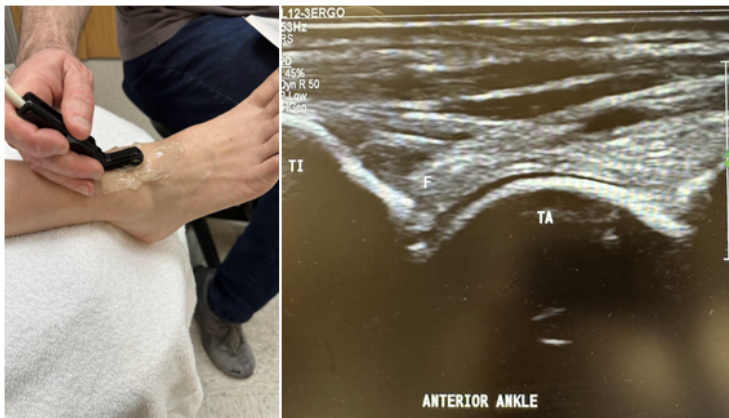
Side-by-side pictures of the transducer position and sagittal image of the anterior ankle, including the tibia (TI), talus (TA), and anterior fat pad (F). The abbreviations given here and labeled on the ultrasound image represent the corresponding structures.
